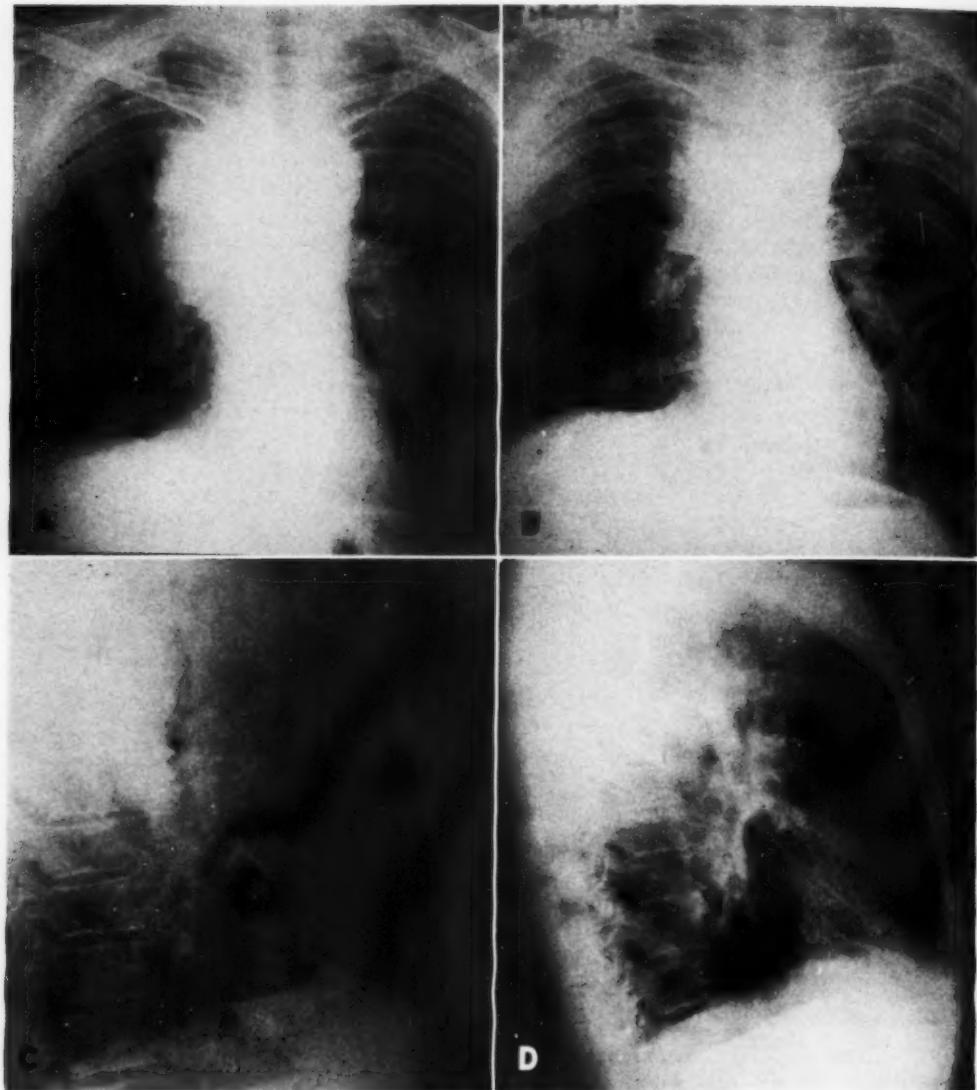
J. K., 63-year-old white male, with severe dyspnea, orthopnea, swelling of head and neck, cyanosis, and distention of superficial veins of neck, thorax, and abdomen. Anaplastic epidermoid Grade IV bronchogenic carcinoma, right upper lobe bronchus. Patient received 4,000 r to the mediastinum in sixty-nine days through two portals, with the grid. Improvement began after 500 r tumor dose and complete remission was accomplished for more than eight months after the single course of roentgen therapy.
